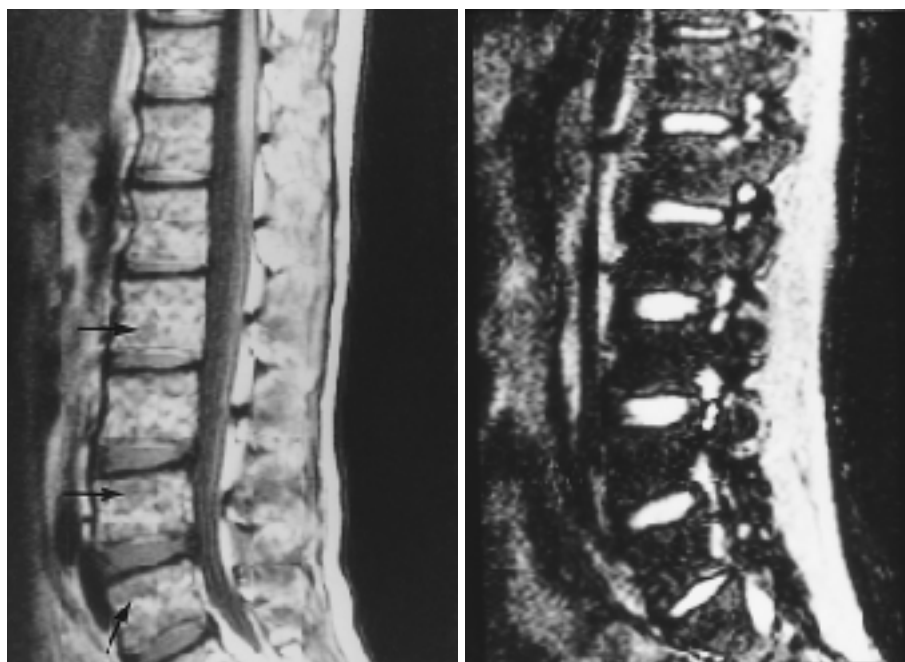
A 27-year-old man(patient No. 15) with labile engraftment syndrome after allogeneic transplantation for acute myelocytic leukemia. Signal intensity of bone marrow is inhomogeneously high with faint low signal intensity areas(arrows) on sagittal T1-weighted image(A, 560/30) of the lumbar spine and low on STIR image(B, 1,200/30/120).
